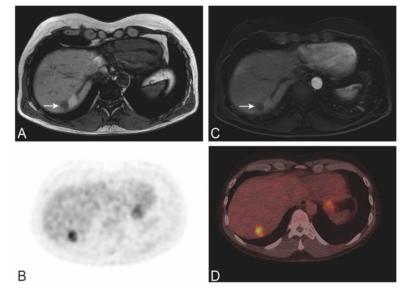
Recurrent disease after liver RFA. Images of T1 weighted MRI before contrast (A), PET (B), contrast enhanced MRI (C) and PET/CT (D).
